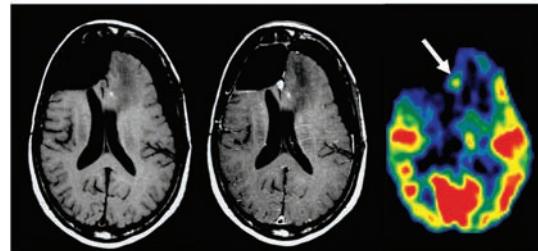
Non-contrast (left) and contrast (center) MR images and FDG PET image (right) after surgical removal of cerebral glioma. Small nodule located in resection border showed high uptake of FDG indicating residual tumor.
